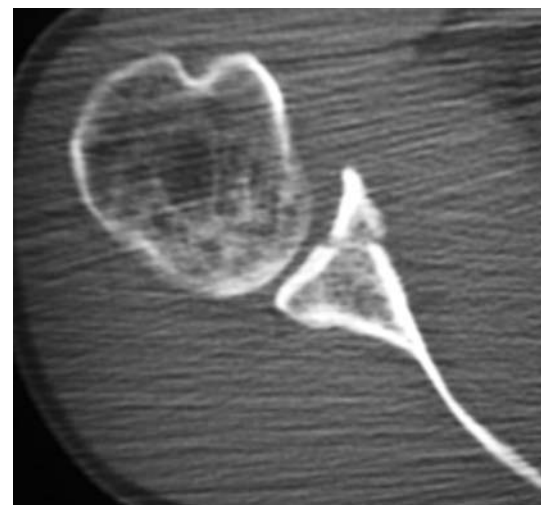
CT scan of the shoulder shown in Figs. 1 and 2 with a large glenoid fragment greater than 25%
